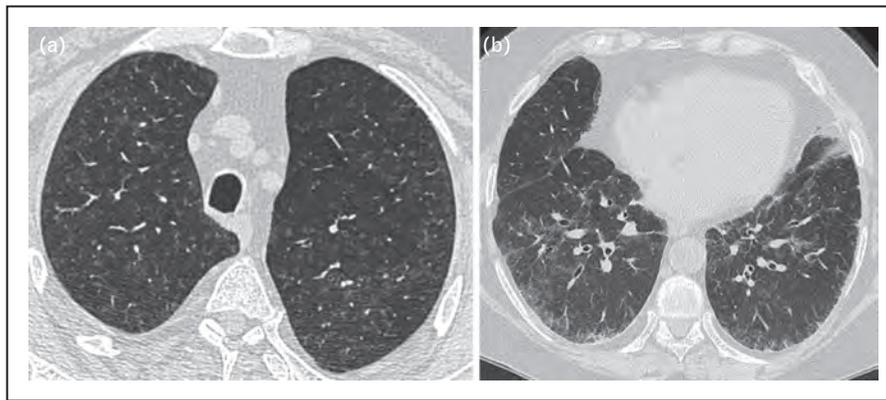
Typical CT appearances in RB/RBILD. (a) CT through the upper lobes demonstrates multiple ‘soft’ centrilobular nodules and patchy ground-glass infiltration. (b) Image through the lower zones in another patient showing, in addition to ground-glass opacities, thickened interlobular septa, lobular regions of decreased attenuation and some thick-walled subsegmental airways.
